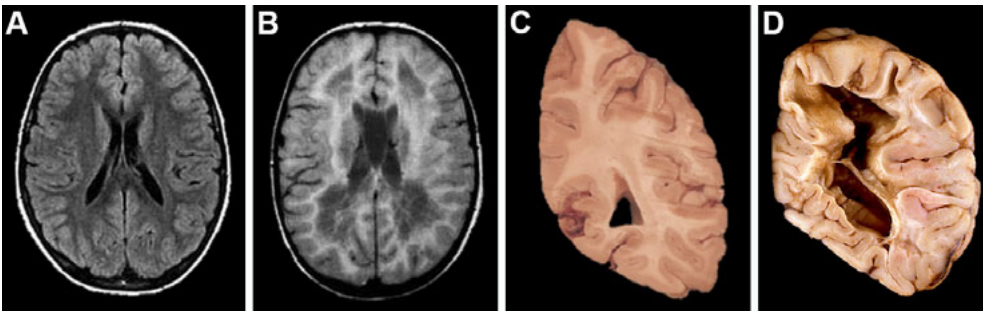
MRI and pathology in VWM. (A) Axial FLAIR image of a control shows a hypointense signal of the cerebral white matter relative to the cortex; (B) in the VWM patient the subcortical white matter has an abnormal hyperintense signal and the deep white matter has a low signal intensity, similar to CSF, indicative of cystic degeneration. (C) Macroscopic coronal section of a cerebral hemisphere in a control and (D) in a VWM patient with end stage disease, showing that virtually all white matter is absent.
